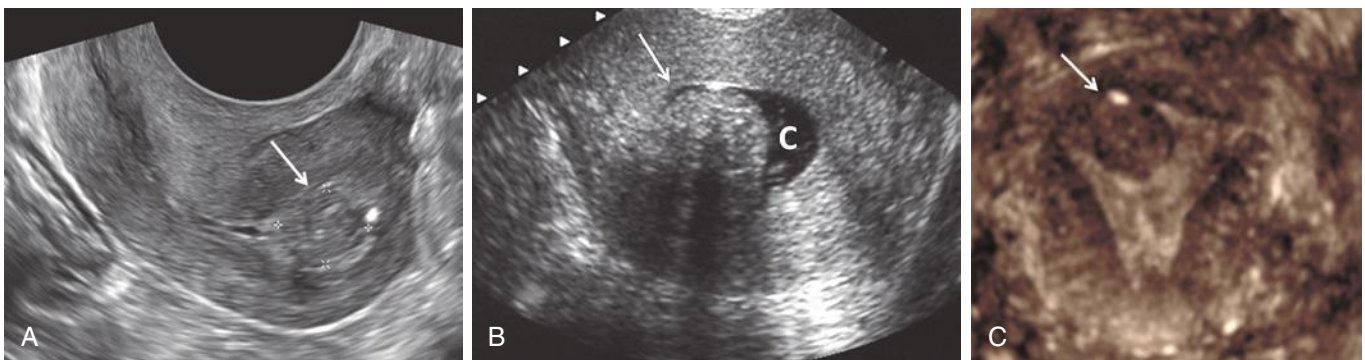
Submucosal leiomyoma. A, Transvaginal sonogram demonstrating a submucosal leiomyoma (*arrow* and *calipers*) that is isoechoic to the myometrium and appears to be intracavitary in the fundus of a retroverted uterus. B, Sonohysterogram with instilled fluid in the endometrial cavity (*c*) partially outlining the protruding submucosal leiomyoma (*arrow*), which demonstrates posterior acoustic shadowing. C, Three-dimensional coronal ultrasound image demonstrates the relationship of the leiomyoma (*arrow*) to the endometrium and confirms that the myoma is predominantly intracavitary.
